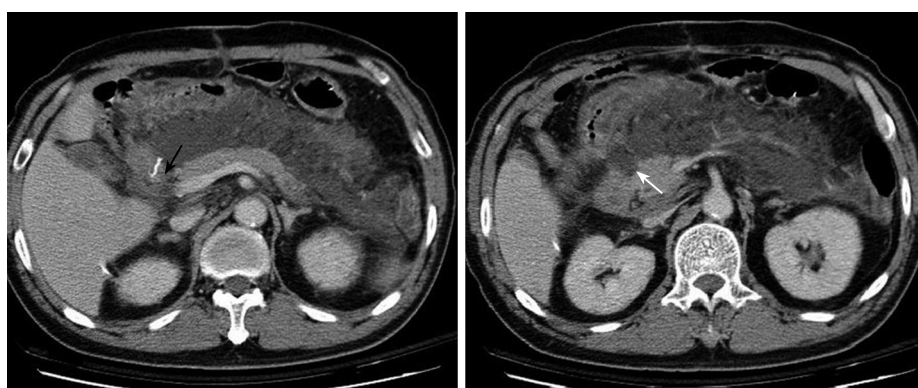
Follow-up abdominal CT after the second operation. Severe fat stranding is seen. An edematous duodenal stump is observed without a clear fat plane surrounding it. This is highly suspicious of a stump leak (black arrow). The loculated fluid with heterogeneous changes indicates the possibility of an abscess formation (white arrow).
